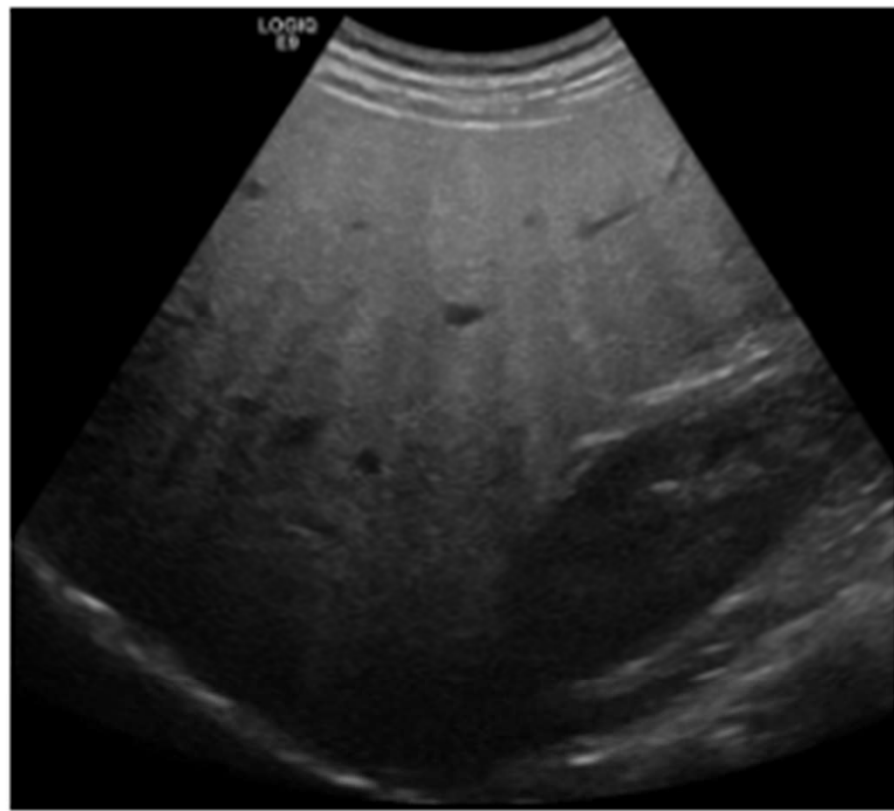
B-Mode sonography with marked increase in fine echoes with poor or non-visualization of the intrahepatic vessel borders, diaphragm, and posterior right lobe of the liver. This finding is pathognomonic for steatosis.
